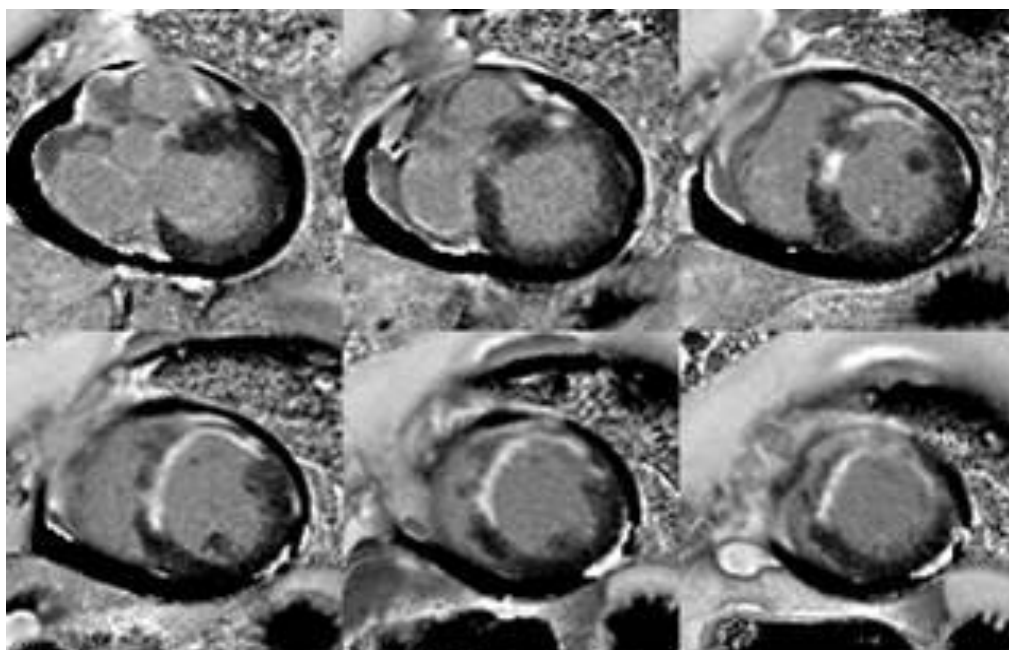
Scar visualization by late enhancement magnetic resonance imaging. White hyperenhanced areas in the septal and anterior wall corresponding to the left anterior descending coronary artery. The expansion of the ischemic injury is starting from the subendocardium and progressing almost to the epicardium, indicating transmural infarction (segmental infarct volume fraction >50%).
